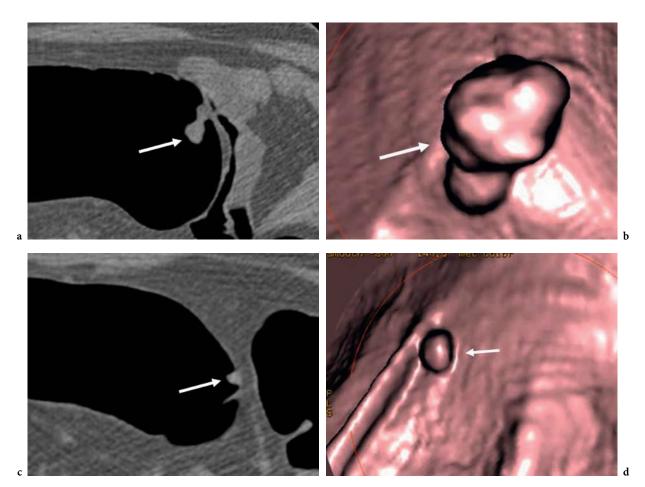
Multi-row CT colonography datasets showing a pedunculated (a, axial; b, endoluminal view) and sessile (c, axial; d, endoluminal view) polyp, located in the sigmoid colon
